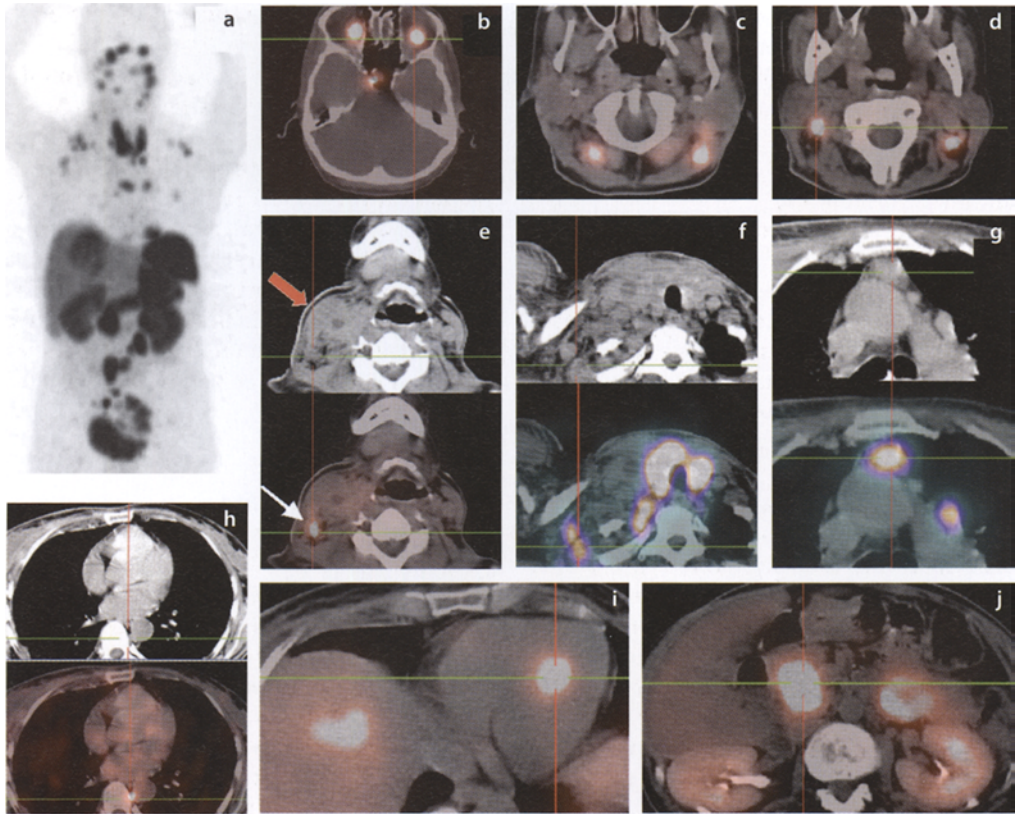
Heavily metastasizing, recurrent bilateral malignant pheochromocytoma: maximum intensity projection (MIP) image (a) and selected transversal Ga-68 DOTA-NOC PET/CT slices showing bilateral retrobulbar metastases (b) and subcutaneous (c) and cervical lymph node lesions (d). Specific uptake can be seen in a small lymph node metastasis in the right neck (e, *white arrow*), whereas a large parajugular abscess shows only blood pool activity (red arrow; see also CT scan). Further metastases are detected in the thyroid and in supraclavicular (f) as well as in mediastinal/para-aortic (g) lymph nodes and in a very small ($\varnothing < 5$ mm) prevertebral lesion (h). PET/CT also revealed a previously unknown myocardial metastasis (i) and strong uptake in multiple abdominal lesion (para-aortic lymph node metastases (j) and in a local recurrence)
